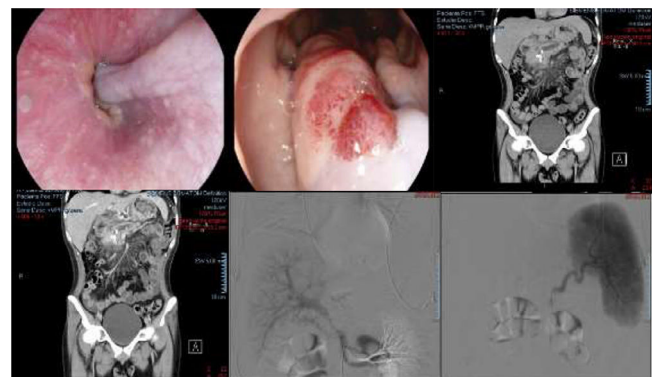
Endoscopy A) esophageal varix B) Thickened gastric folds with areas of subepithelial hemorrhage. Contrast-enhanced CT c) Intraductal calcifications and dilation of the main duct. d) Gastric enhancement is observed after contrast administration of perigastric veins. Arteriography and portography E) proximal portal vein stenosis F) splenic vein stenosis.
